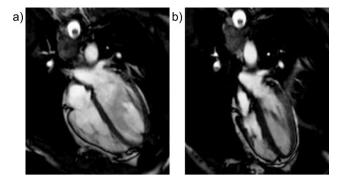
Cardiac MRI (MR Phillips 1.5 T, 4-chamber view) was performed at rest (a) and after "lung packing" with a subsequent 2-min apnea (b). At the end apnea, both right and left ventricular volumes were significantly reduced, likely due to both reduced venous return and increased intrapulmonary pressure. Thus, ventricular wall thicknesses were markedly increased.
